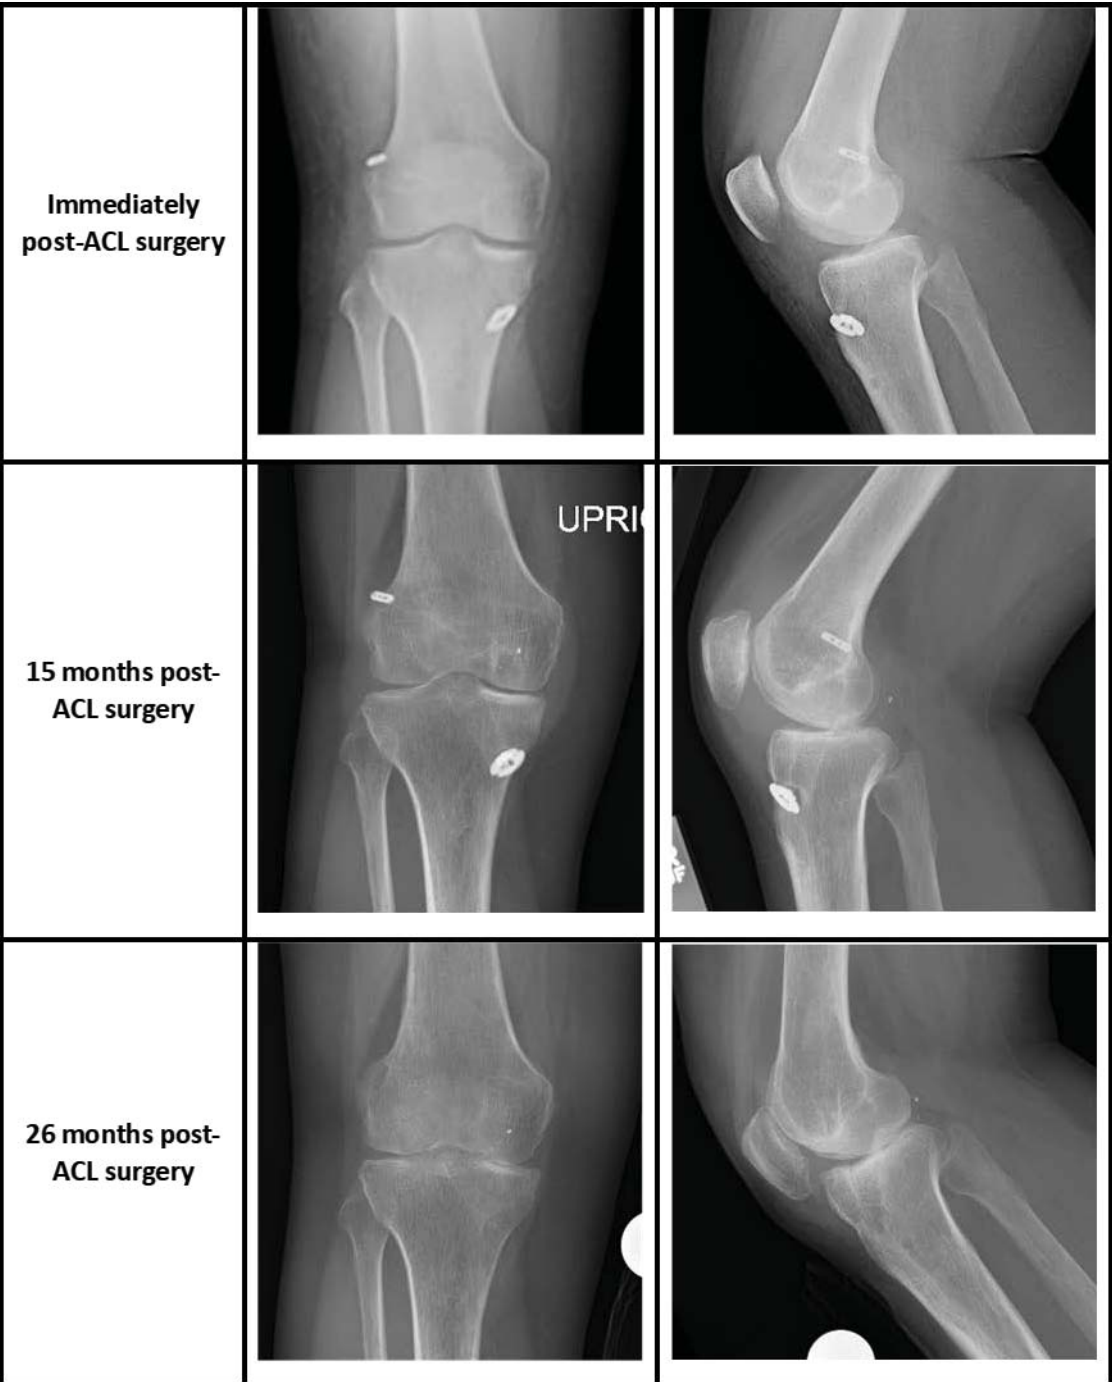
Radiography of the right knee showing rapid onset of degenerative changes.
